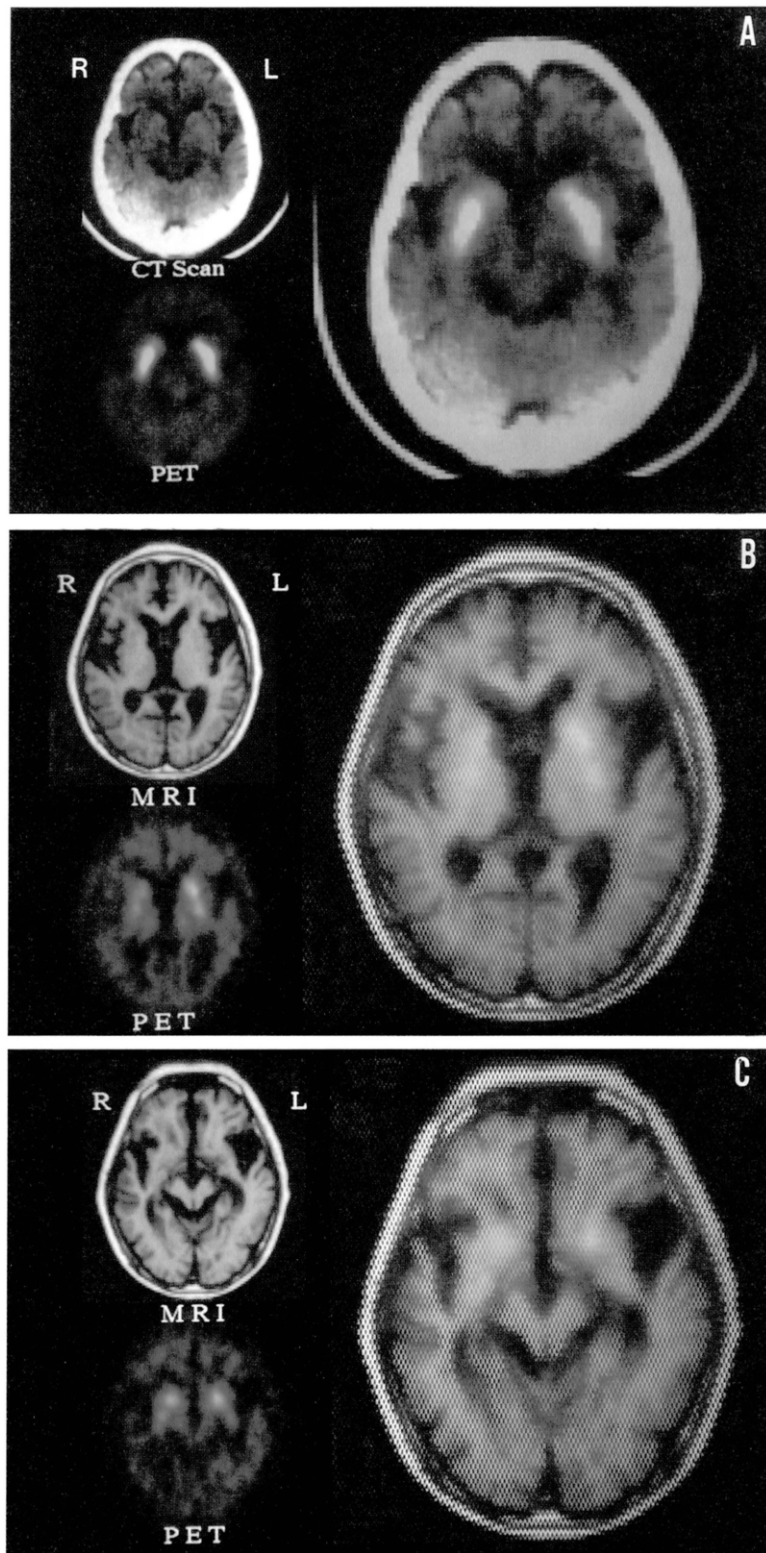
Two different images obtained using [18 F]-6-fluorodopa (FDOPA) positron emission tomography and computed tomography or magnetic resonance at the level of the caudate nucleus and the putamen from a normal control (A) and from the patient with corticobasal degeneration (B, C). FDOPA accumulation was decreased in the caudate nucleus and the putamen. This decrease was more severe on the right side of the brain than the left.
